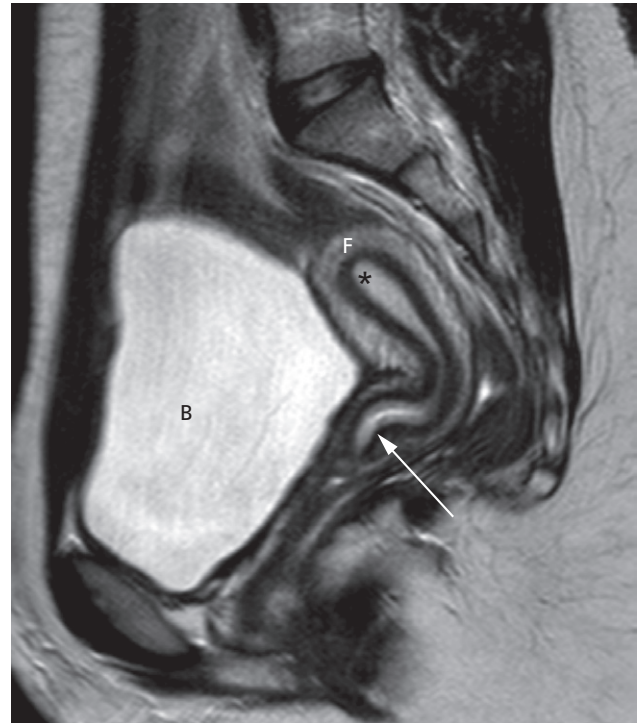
Normal uterus on sagittal T2-weighted MRI. The endometrium (*) returns a high signal intensity. The cervix (white arrow) is in continuity with the lower uterine body. B, bladder; F, uterine fundus.
